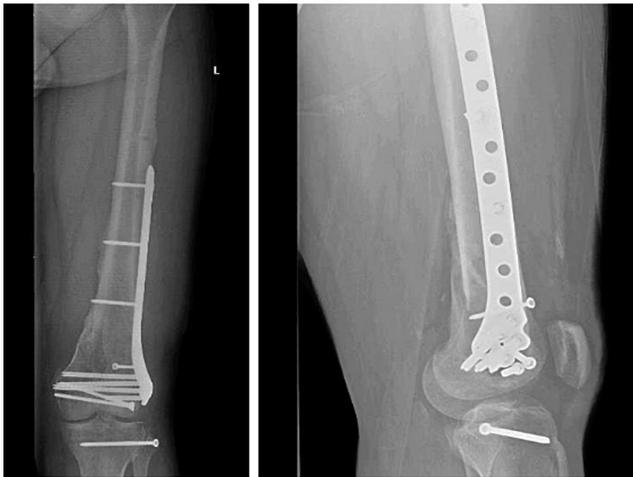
Anteroposterior (left) and lateral (right) radiographs at 8 months follow-up show hardware in place with acceptable alignment and healed femur fracture with callus formation. Patient was full weight bearing at this point, denies any pain and regained full knee range of motion.
